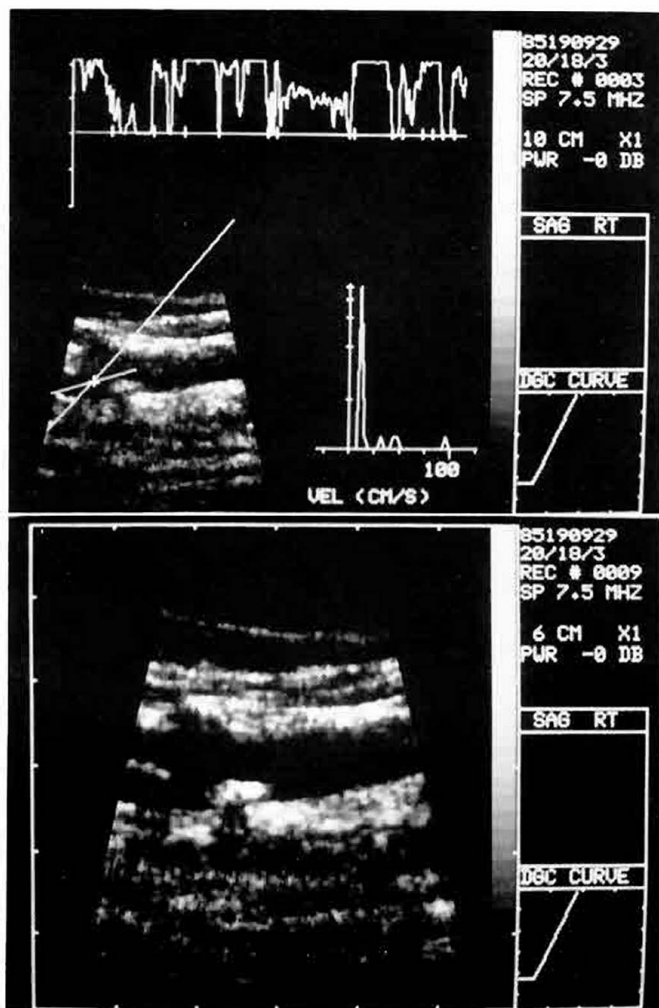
A duplex mixed mode display shows Doppler analysis proximal to the plaque of right carotid bifurcation. The display allows simultaneous B-scan imaging and Doppler spectral analysis from a known location in the stenotic area. Turbulent flow is easily identified by the irregular Doppler wave forms. The quantitative histogram displays the average velocity of blood flow.
